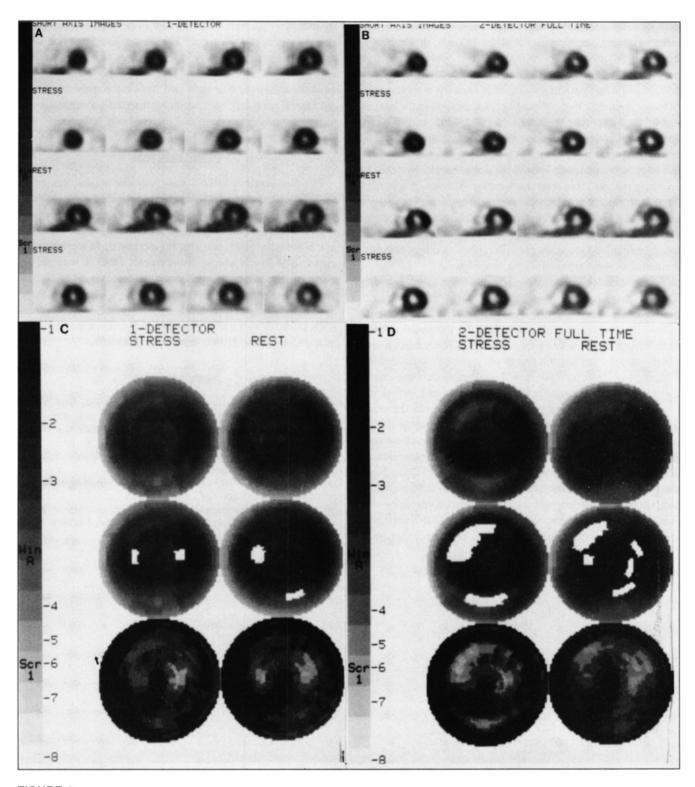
Patient with stenoses of the left anterior and right coronary arteries, documented by contrast angiography undergoing both stress/rest SPECT using the single-detector camera and the two-detector camera, full-time acquisition. (A) Short-axis stress and rest tomograms from the single-detector study. (B) Short-axis stress and rest tomograms from the two-detector full-time study. (C) Raw polar coordinate plots (top row), extent maps (middle row) and severity maps (bottom row) from the single-detector study. Only questionable abnormalities are identified. (D) Same as (C), but for the two-detector, full-time study. Two-vessel ischemia is more readily apparent.
